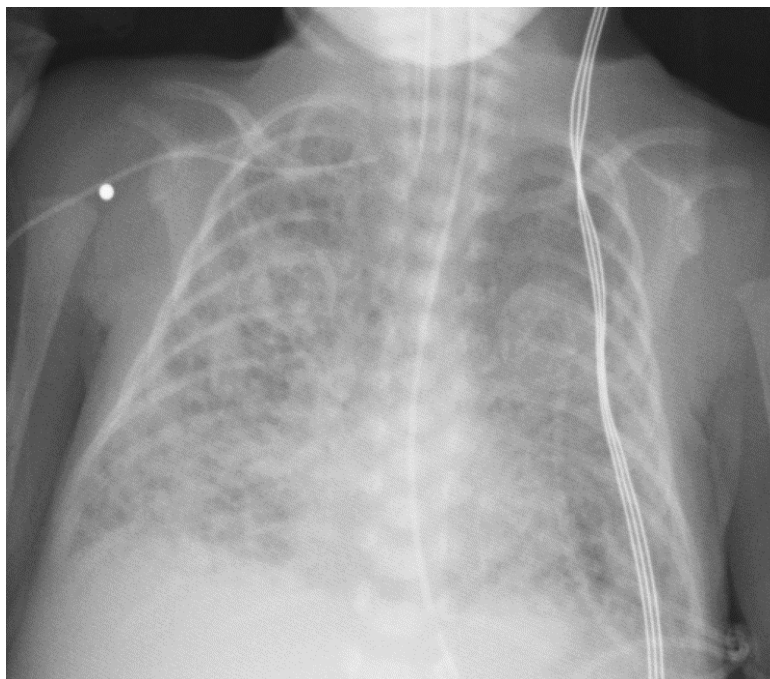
Day 8 Chest x-ray suggestive of bilateral pulmonary interstitial emphysema (PIE) with hyper expanded lung fields
